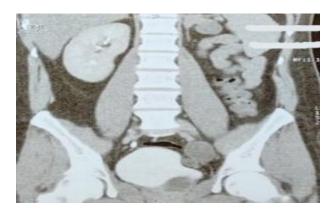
Coronal CT KUB images showing left renal agenesis with a seminal vesical cyst.
